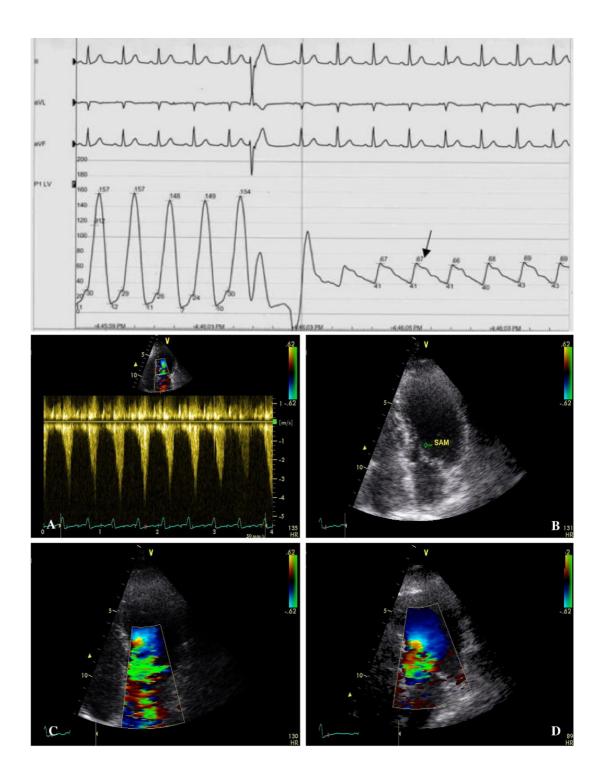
Upper panel depicts hemodynamic tracing in a patient with obstructive TTC: on pullback of pigtail catheter from LV to aorta, a gradient of ~70mmHg is apparent; arrow shows bifid aortic waveform ("spike and dome") characteristic of dynamic left ventricular outflow tract (LVOT) obstruction (*Reproduced from Fefer et al, 2009*). Middle and lower panels demonstrate typical late peaking pattern of LVOT obstruction on continuous wave Doppler (A), together with systolic anterior motion (SAM) of the mitral valve in apical 4-chamber view (B) and associated mitral regurgitation (C), in the same TTC patient. Dynamic LVOT obstruction and mitral regurgitation disappeared with intravenous propranolol (D) (*Reproduced from Panigada et al, 2009*).
